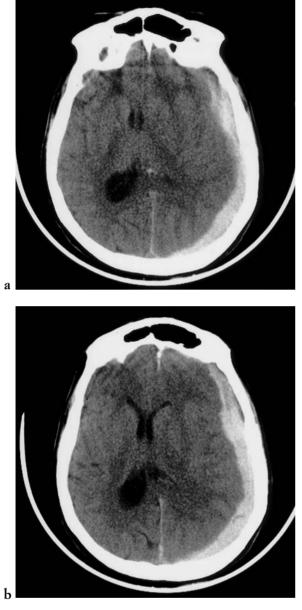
Axial CT demonstrates an acute subdural haematoma along the left hemisphere convexity with right shift of the midline structures and compression of the left lateral ventricle. [a), b) axial CT].
